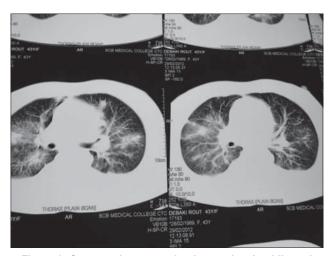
Computed tomography thorax showing bilateral nodular lesions, ground glass opacity and cavity left upper lobe in granulomatosis with polyangitis (Case 1)
